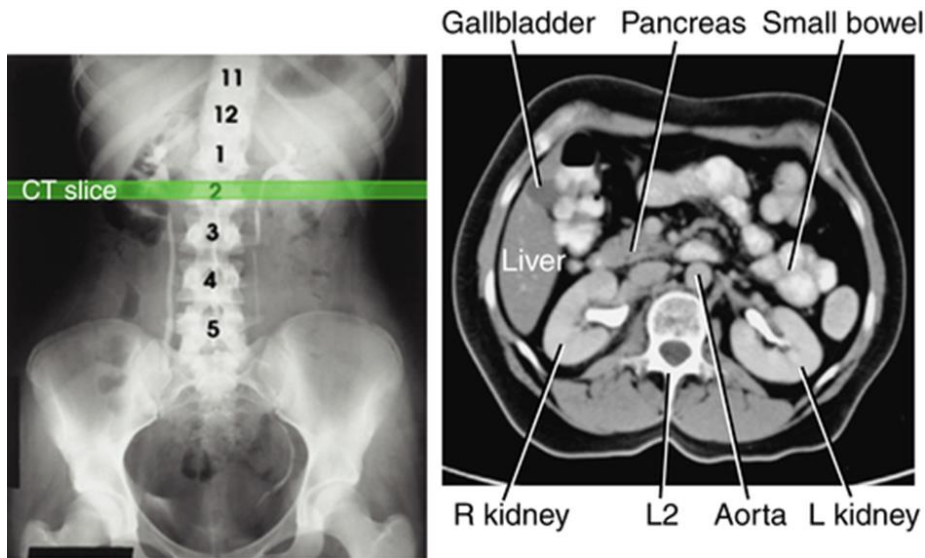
Computed tomography principles.
